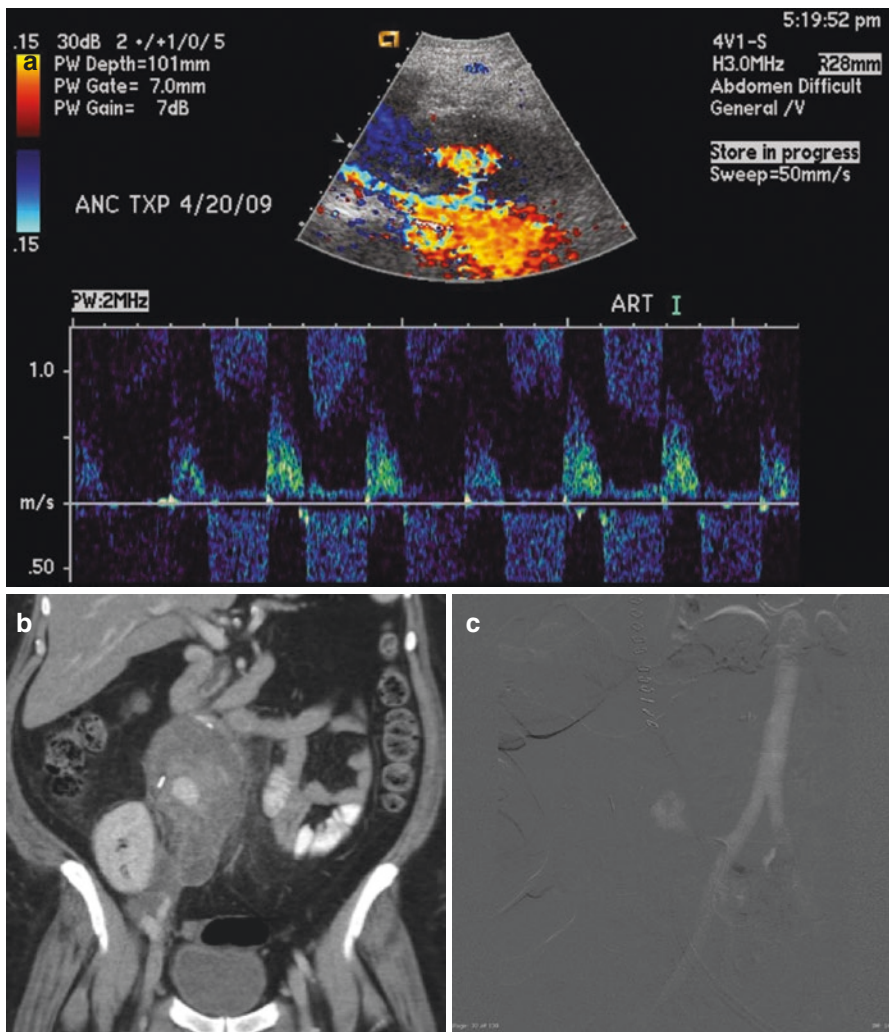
(a) Doppler ultrasound image of the transplant artery shows a pseudoaneurysm (arrow). There is to-and-fro flow within the neck of the pseudoaneurysm. (b) Coronal reformatted of the contrast-enhanced CT shows the pseudoaneurysm of the transplant pancreas artery (arrow). (c) This is an image from CO2 angiography. This is a pseudoaneurysm (arrow) arising from the Y graft of the pancreas transplant
